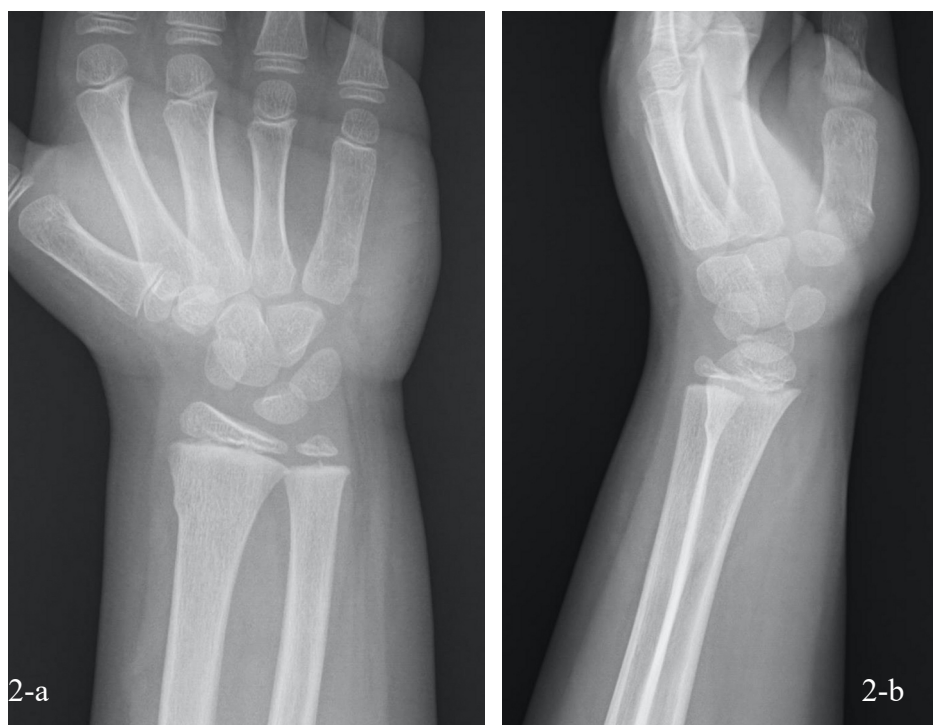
AP and lateral radiographs showing a torus fracture in the distal radius
